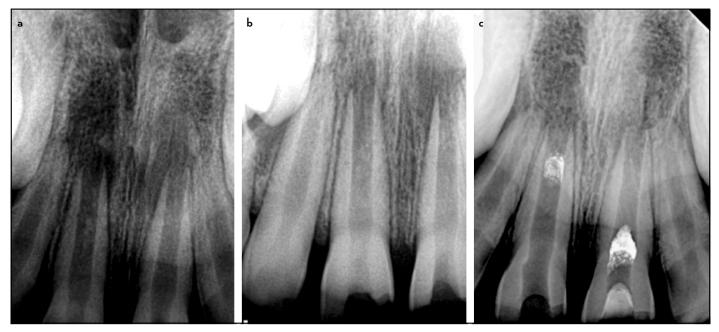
(a, b) Pre-operative periapical (PA) radiographs with straight and shifted projections, respectively showing immature roots of teeth 11 and 21 associated with radiolucency indicative of apical periodontitis. (c) PA radiograph at 11 months after starting the treatment. The PA radiograph shows the loss of temporary restorations and the increase of size of periapical radiolucency with no changes in the dimensions of the roots
